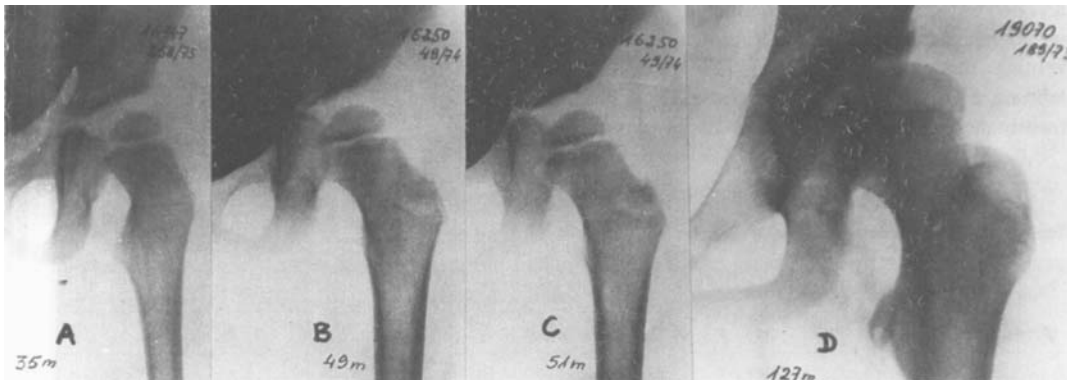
Surgically treated residual dysplasia. Preoperative radiographs. A age 35 months, score 10. B age 49 months, score 14. C age 51 months, score 16. D age 127 months, score 7. Cases A, B and C are doubtful surgical indications. In case D surgery was performed too late.
